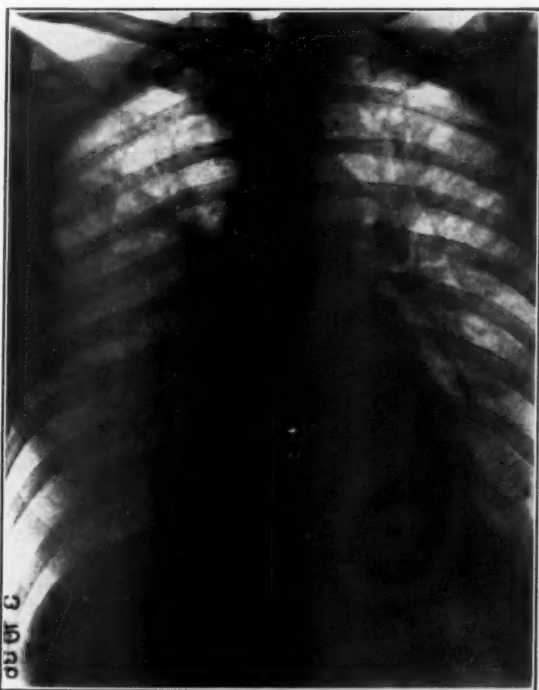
Roentgenogram of the chest showing increased hilus shadows with fanlike radiation toward the periphery.
